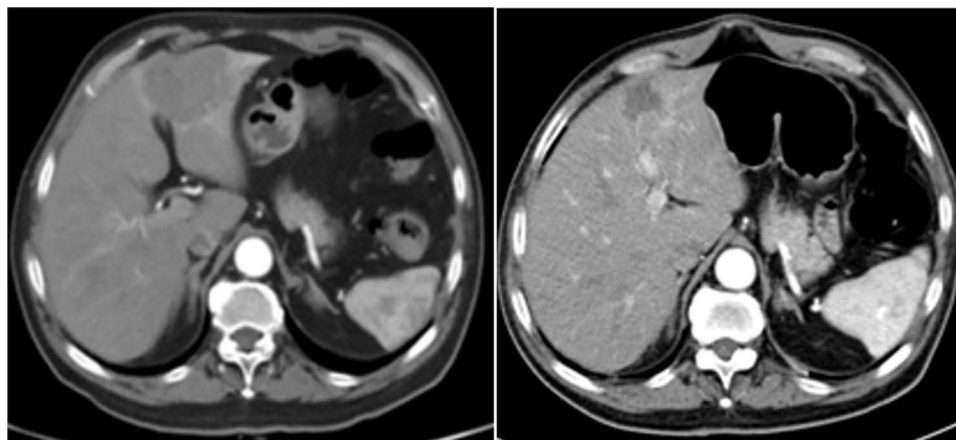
The CT scan results of the changes for target lesions in liver sites of one patient with metastatic colorectal cancer before and after the administration of anlotinib plus tislelizumab.
